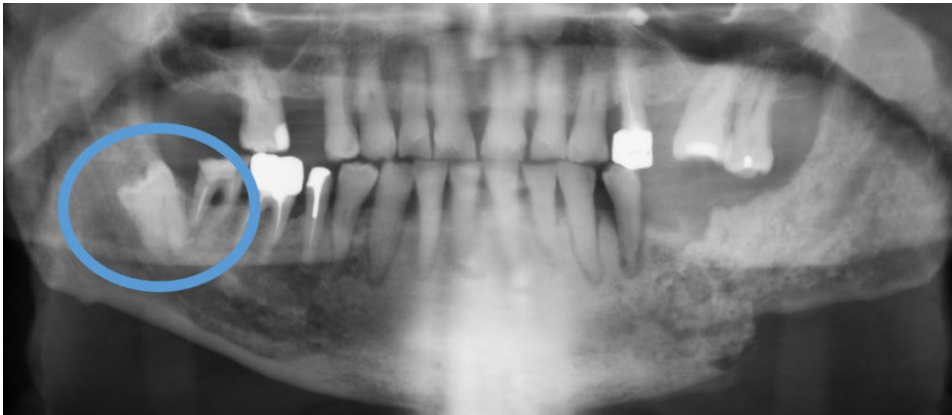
Left mandibular osteolytic lesion on orthopantomogram in a patient with plasmacytoma.
